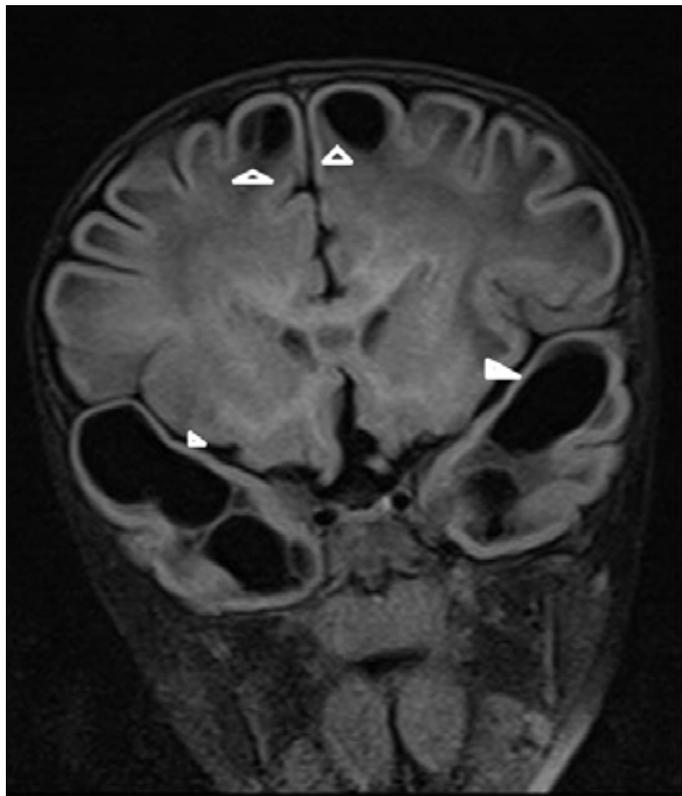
Giant subcortical cysts on performing brain magnetic resonance imaging
